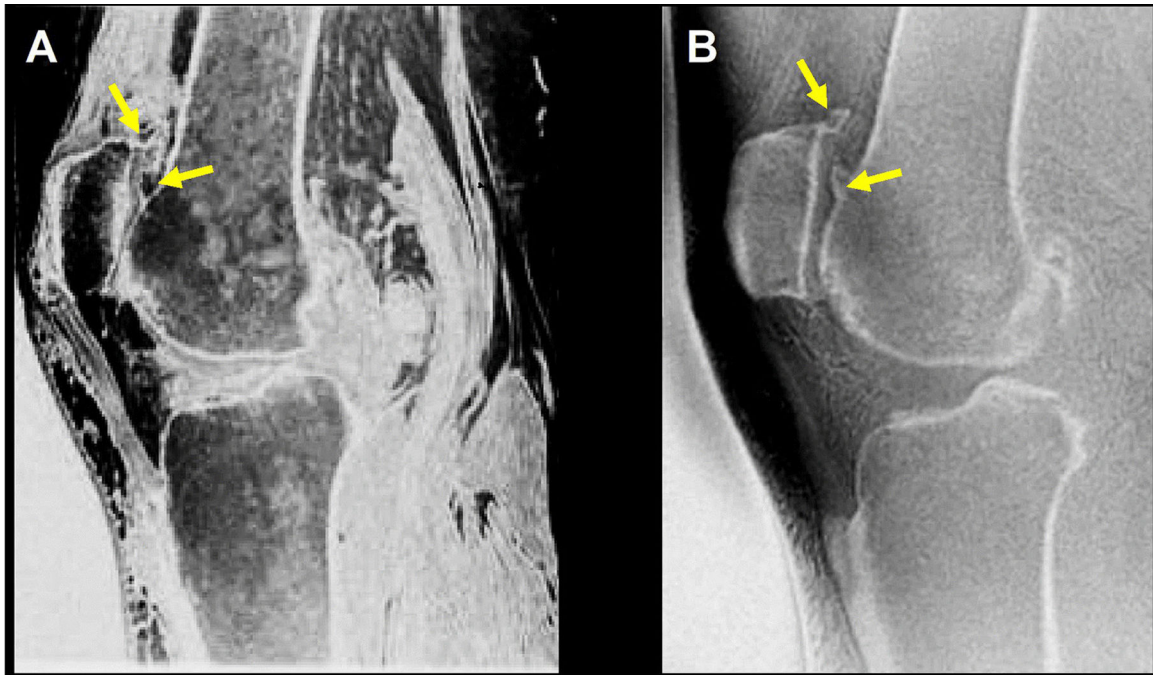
61-year-old woman presented with left knee pain and MRI shows degenerative changes with prominent osteophytes. SPGR (A) and ZTE (B) sequences. Superior femoro-patellar osteophytes (arrows) are well-characterized on the ZTE sequence (B) but are not well-visualized on the SPGR sequence (A)
